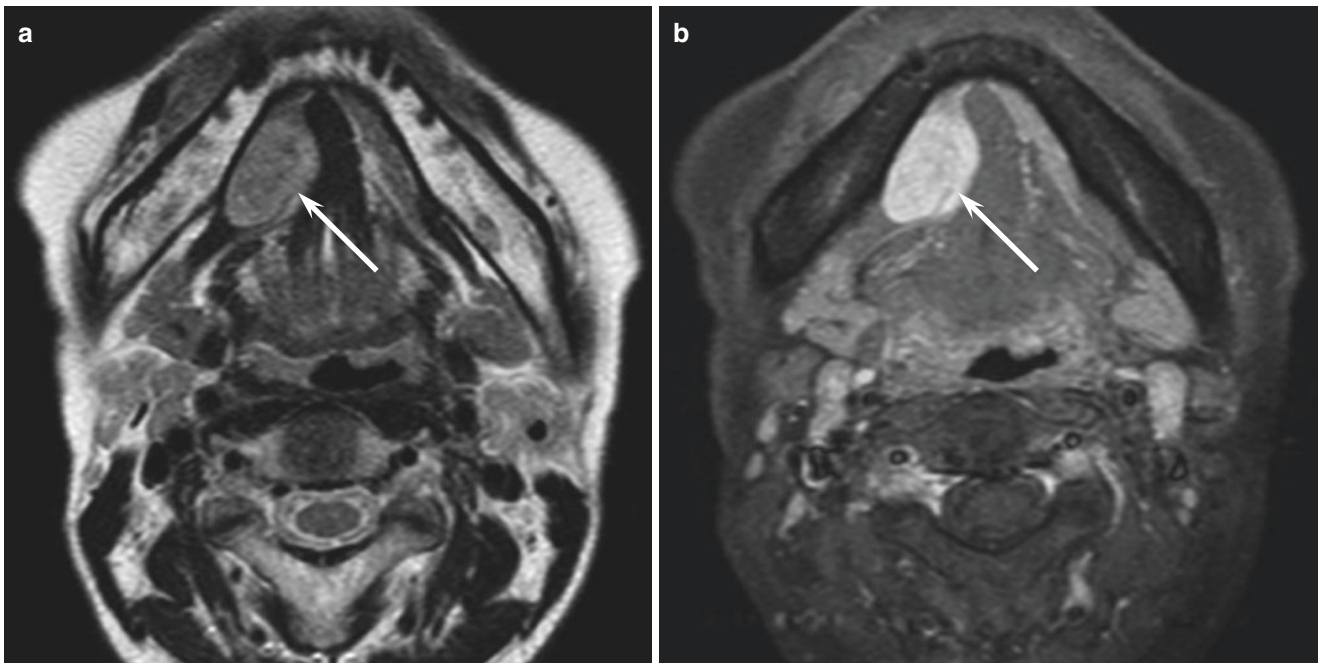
A 55-year-old woman with adenoid cystic carcinoma of the right sublingual gland. (a) T2-weighted image shows a well-demarcated, homogeneously hyperintense lesion (arrow). (b) Fat-suppressed
